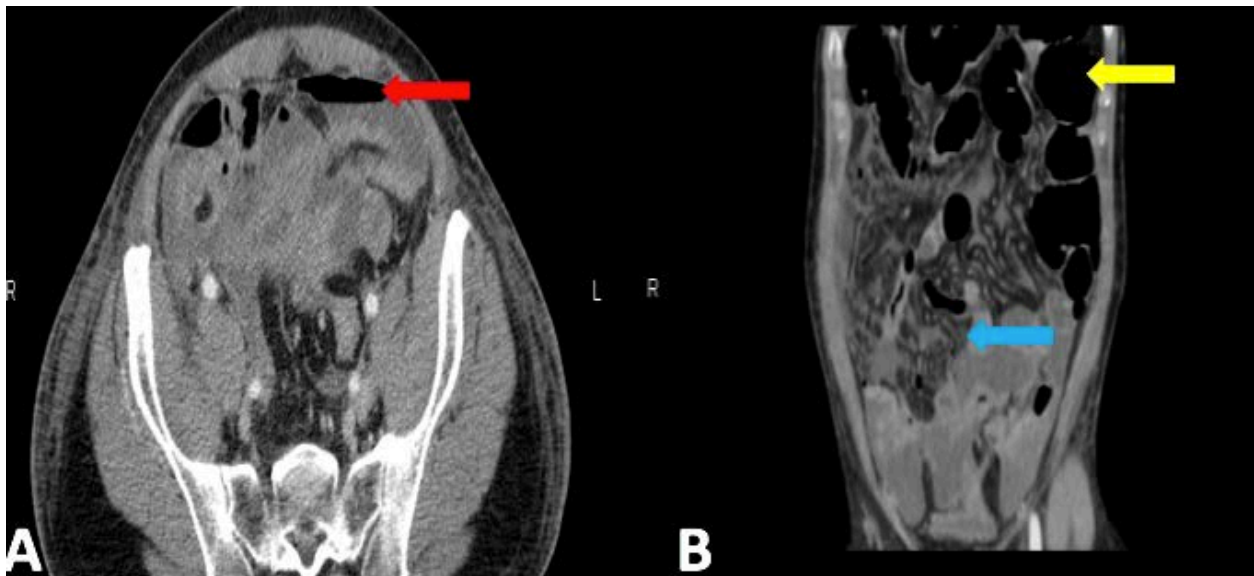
Abdominal CT-scan showing pneumoperitoneum (red arrow) with ascites (blue arrow) and dilated jejunum (yellow arrow).
